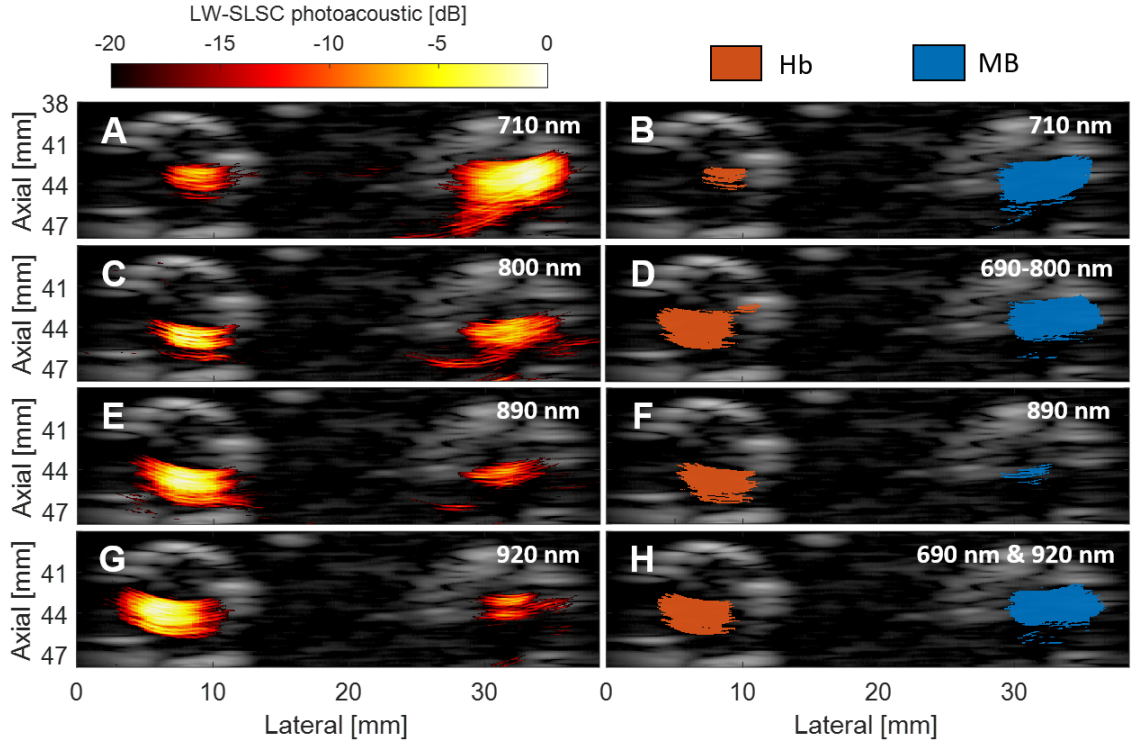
Locally-weighted short-lag spatial coherence (LW-SLSC) photoacoustic images overlaid on DAS ultrasound images of MB and Hb, obtained with a laser wavelength emission of (a) 710 nm (c), 800 nm (e) 890 nm, and (g) 920 nm. Segmented masks for MB and Hb after a -10 dB threshold was applied to the LW-SLSC photoacoustic images with single-wavelength masks shown for wavelengths of (b) 710 nm and (f) 890 nm, (d) the compound mask from “OR” logical operation on masks generated from 690 nm to 800 nm, and (h) the resulting mask from the “OR” logical operation of the 690 nm and 920 nm masks.
